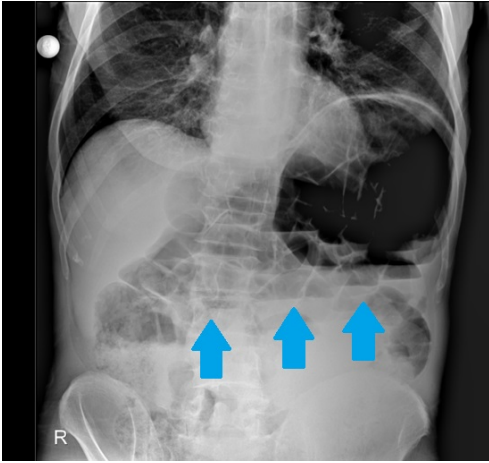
An abdominal radiograph shows signs of a distended small bowel (the blue arrows)
